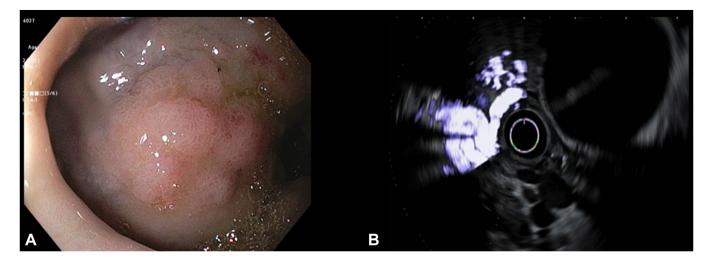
A, EUS showing positive Doppler signal. B, EGD showing large blebs with blue hue in duodenal bulb.
